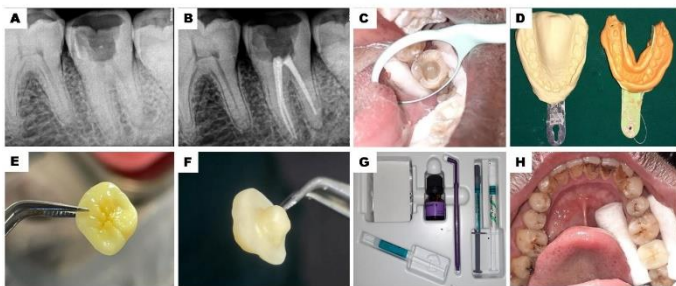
[A] PREOPERATIVE RADIOGRAPH [B] POSTOPERATIVE RADIOGRAPH [C] ENDOCROWN PREPARATION [D]PUTTY IMPRESSION [E, F] ENDOCROWN [G] RESIN CEMENT [H] ENDOCROWN CEMENTATION DONE.
